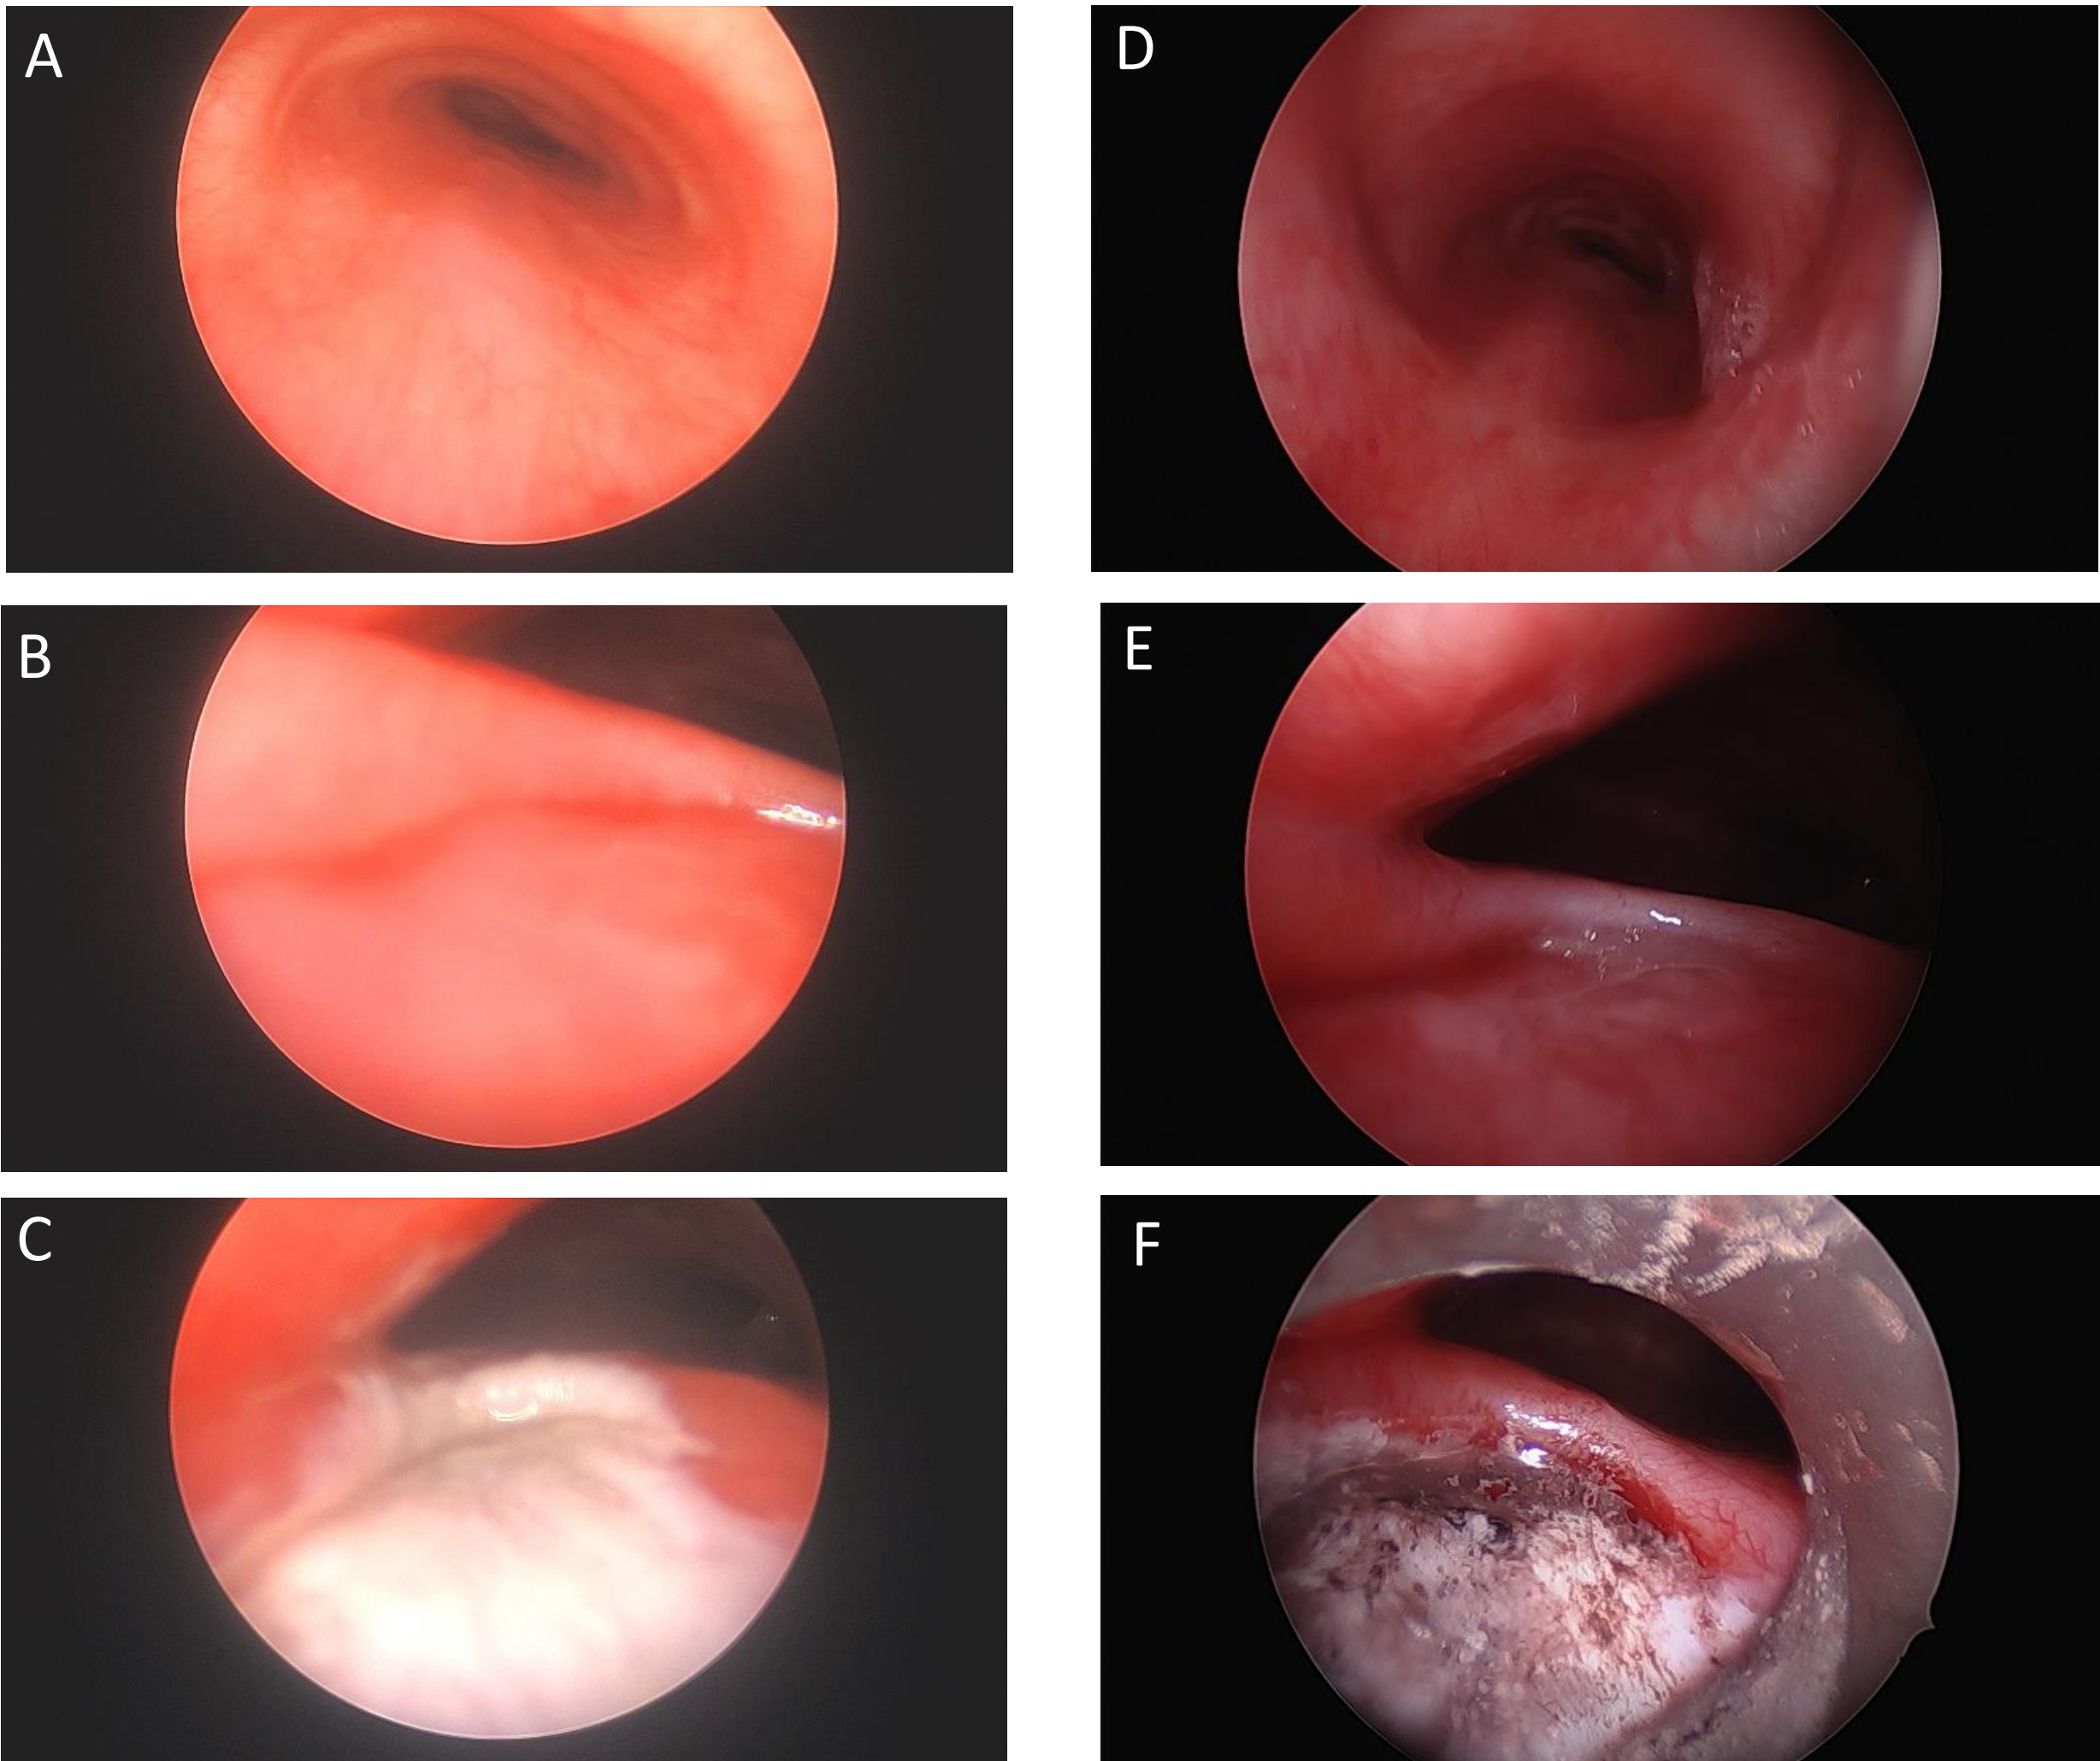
17-year-old patient with VACTERL syndrome who had undergone repair of H-type TEF as an infant who presented with recurrent pneumonia. CT evaluation showed possible recurrent TEF (rTEF). Although there was no definitive leakage demonstrated on esophogram. He was taken to OR for chemocauterization with TCA three times (01/08/24, 02/09/24, 04/10/24).
